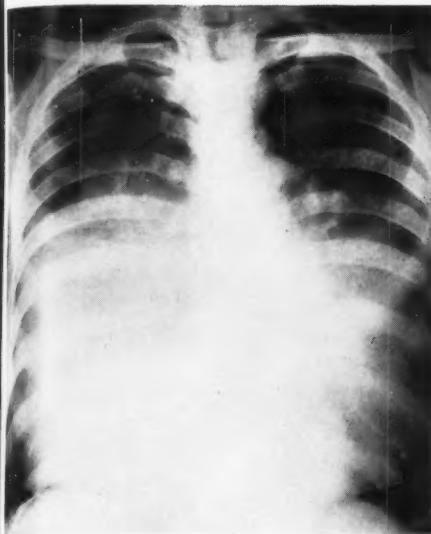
P.A. X-ray of chest showing mediastinal lipoma.
